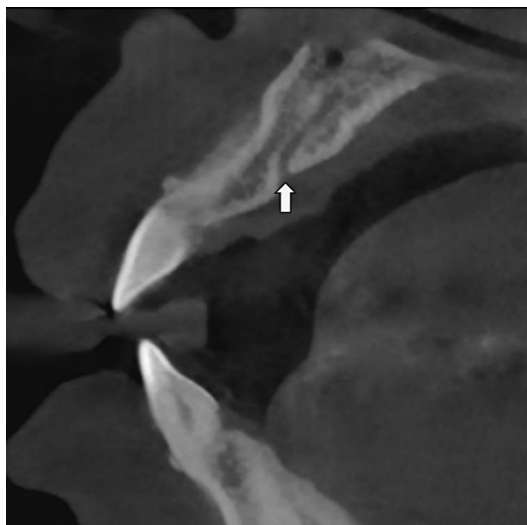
Sagittal CBCT slice showing the presence of canalis sinuosus in the left side of the anterior maxilla.
